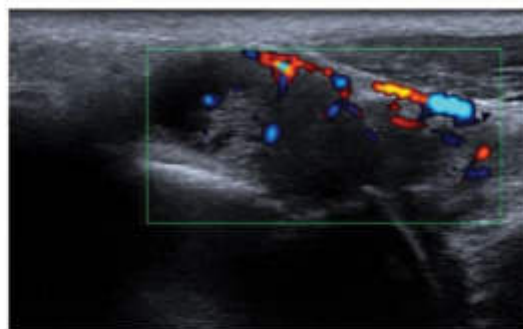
Developing erosion filled with a hypertrophic synovial membrane with increased vascularization and effusion on ultrasound
